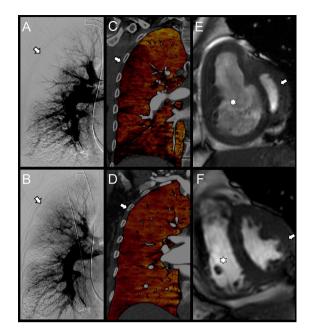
Post-balloon pulmonary angioplasty imaging follow-up. (A-D), Pre- and sixmonth post-balloon pulmonary angioplasty (BPA) imaging in a 66-year-old woman with confirmed chronic thromboembolic pulmonary hypertension (CTEPH) treated with four BPA sessions due to residual disease after surgery. (A) Pre-BPA digital subtraction pulmonary angiography (DSA-PA) and (C), dual-energy CT-pulmonary angiography (DECT-PA) iodine perfusion mapping shows anterior and posterior segmental perfusion defects in the right upper lobe (arrow in \mathbf{A}) and lack of lobar perfusion in the iodine map (arrow in C). (B), DSA-PA and (D), DECT-PA after BPA demonstrate patency of the anterior and posterior segmental branches, with restoration of pulmonary perfusion (arrows). (E-F), 76-year-old woman with confirmed CTEPH treated with five BPA sessions due to refusal of surgical treatment who underwent pre- and post-BPA cardiac short-axis cine SSFP MR images. (E), Cardiac MR image reveals severe dilatation of the right ventricle (asterisk), as well as hypertrophy of the free wall of the right ventricle and marked flattened interventricular septum (arrow). (F), Post-BPA cardiac MR image shows significant improvement in right ventricular dilatation (asterisk) and interventricular septal morphology (arrow).
